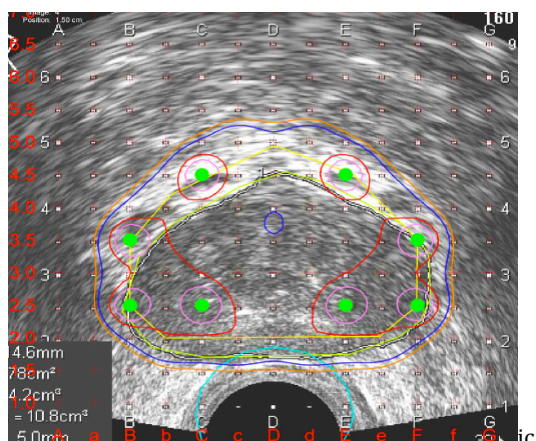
Plan of an implant overlaid on ultrasound image of the prostate gland.
